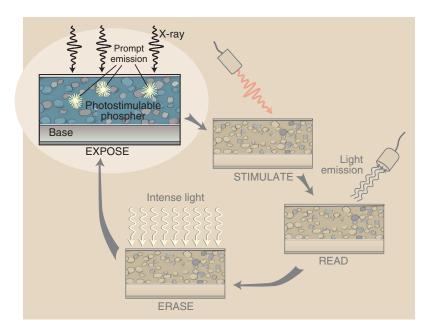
Expose*: The first of a sequence of events that results in an x-ray-induced image-forming signal.
